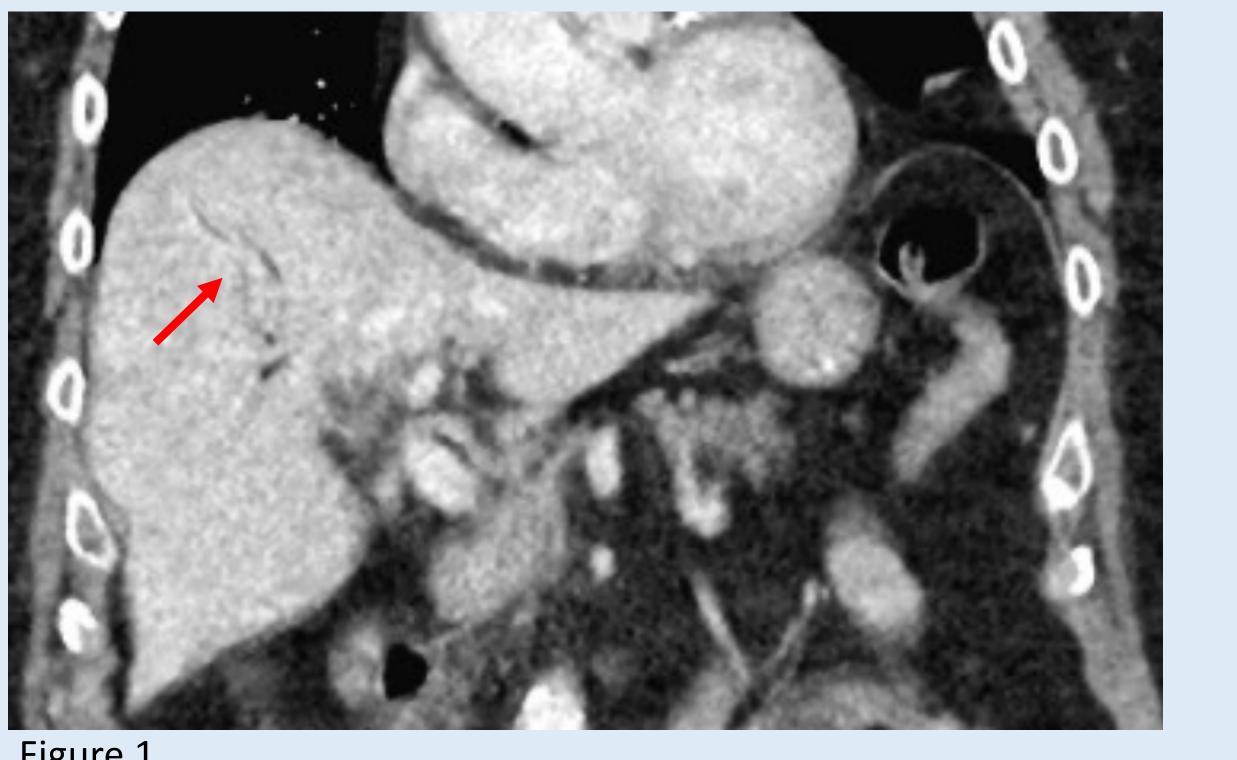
Abdominal CT revealed pneumobilia of uncertain etiology.
